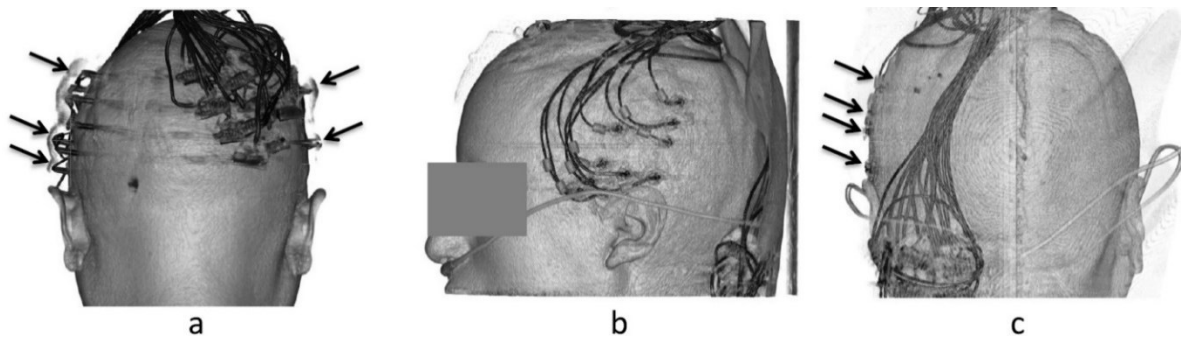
Comparison of the depth electrode holding screws for the two patients. Reconstructions were obtained from post-implantation CT scans. (a) Rear view of the reconstruction for the patient 1 (with long screws). (b) and (c) Reconstruction for short screws on profile and rear view respectively for patient 2. Figure from *Technical solutions for simultaneous MEG and SEEG recordings: towards routine clinical use* Badier et al. (2017). Reprinted with permission from IOP Publishing.
